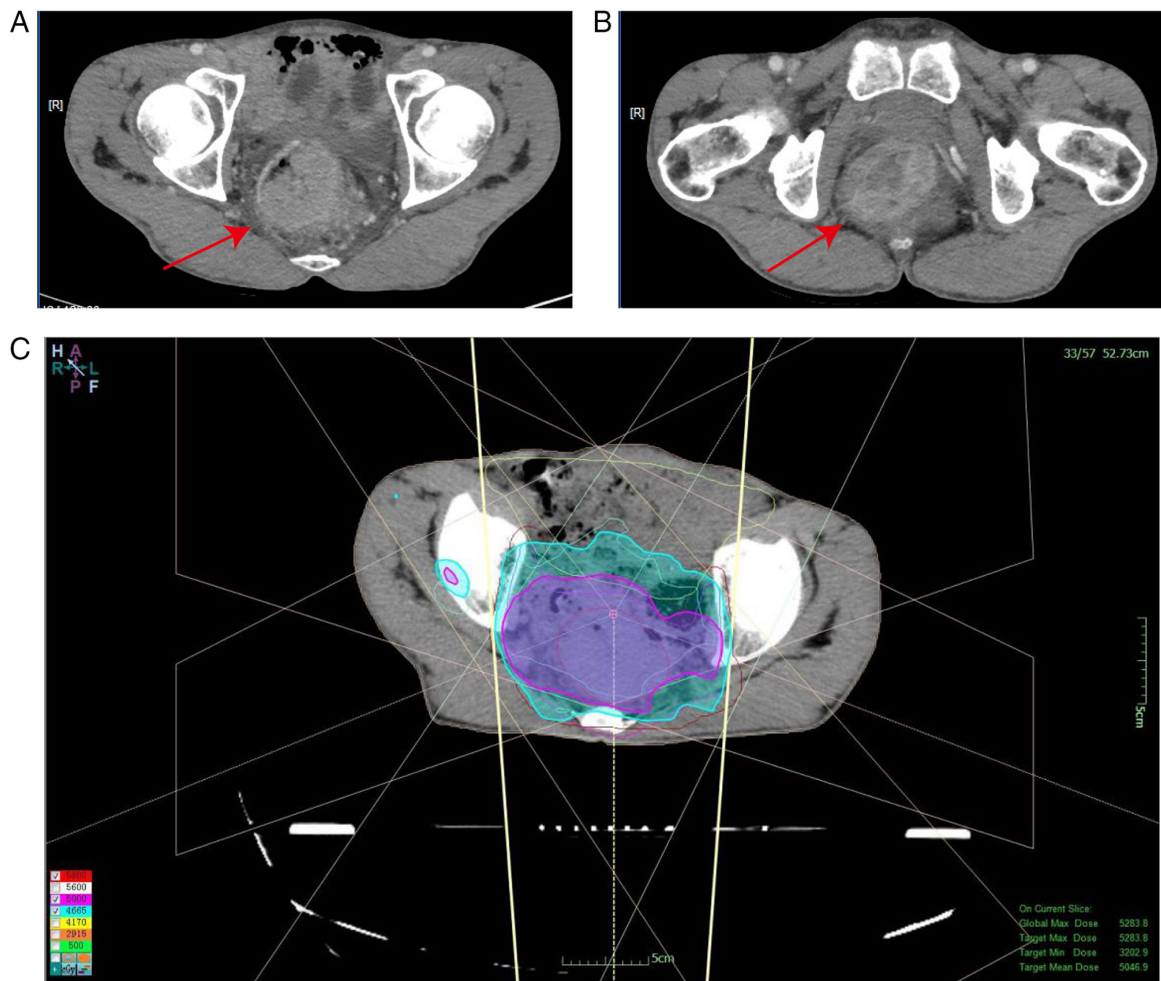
Initial computed tomography imaging in February 2019. Initial detection of rectal mass (red arrow) by CT scan at (A) higher and (B) lower pelvic level. (C) Target volume and dose distribution map of rectal cancer overlapped with the secondary sarcoma area. The colored lines represent various radiation isodose levels
